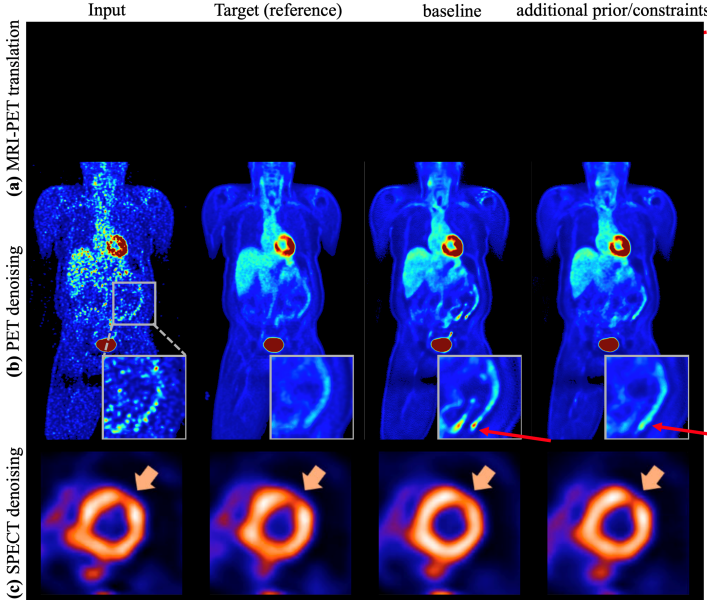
Examples of hallucination mitigation using additional constraints or priors. (a) MRI-to-PET translation incorporating multi-modal and clinical prior information (please refer to Fig. 1 in (30)). (b) PET denoising using anatomical and metabolic priors to regularize generation (53). (c) SPECT denoising guided by a task-specific loss function informed by perfusion defect detection (reprinted from (54), licensed under CC BY 4.0).
